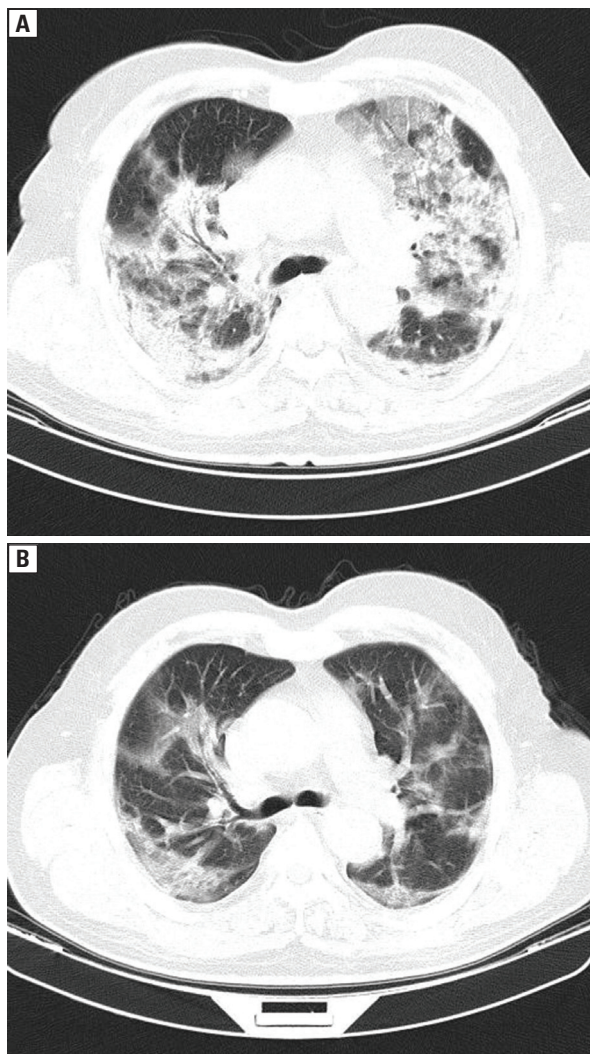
A. Early imaging (at admission) of a 73-year-old man without a positive history for any comorbidity, presenting about 7 days after the onset of respiratory symptoms. Non-enhanced chest CT shows sub-pleural mixed pattern of infiltration. B. Follow-up CT scan performed after 8 days shows extensive consolidation and bronchial dilation. The patient recovered after 10 days from admission and was discharged in good clinical condition
